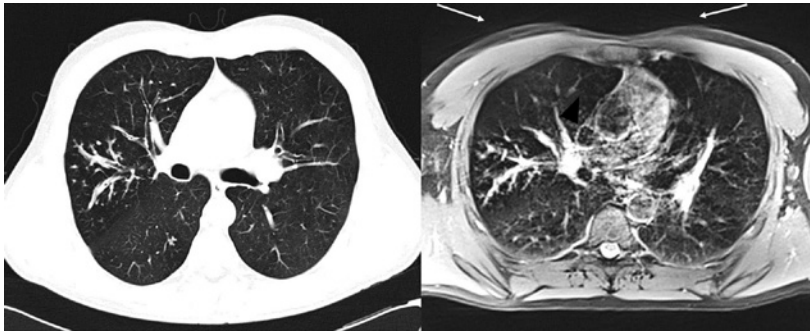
Motion Artifacts of MRI PROPELLER (BLADE@Siemens). Note the motion artifacts around the heart (white arrows)
